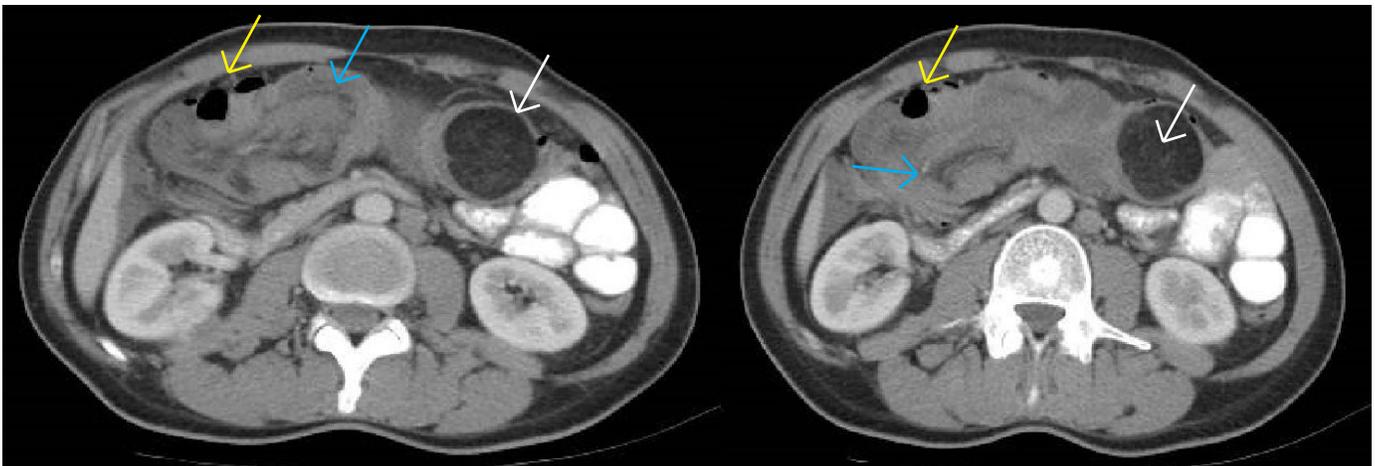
Abdominal CT showing transverse colon lipoma (white arrow) acting as a leading point of a colocolic intussusception. The intussusception segment measured about 11.5 cm (blue arrow) with ischemic changes and intramural gas (yellow arrow).
